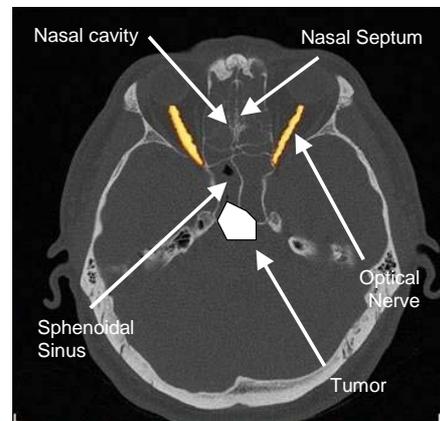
Transnasal approach to the tumor in the pituitary gland, depicted in an axial CT slice of a head..*
